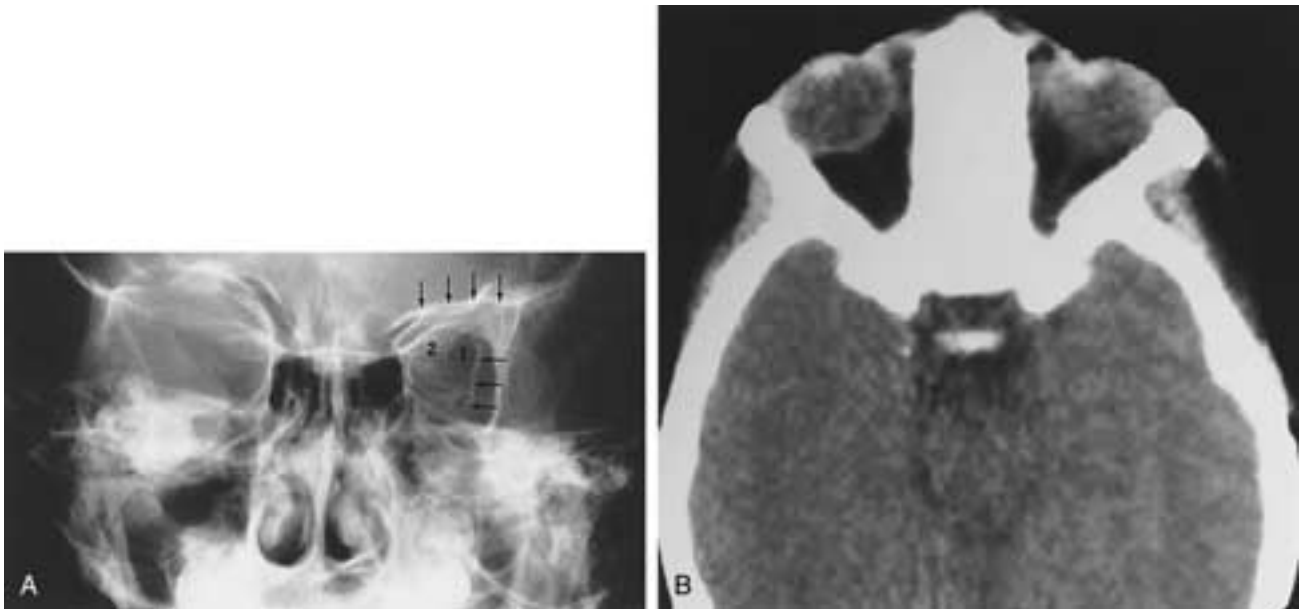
A, Microphthalmia. Posteroanterior view of the skull. The lesser wing of the sphenoid (2) and the left maxillary sinus are hypoplastic; superior orbital fissures are asymmetric (I). Note the difference between the oblique lines (*horizontal arrows*), which represent cortices of the temporal surface of the greater wings of the sphenoid bone. Notice the hypoplasia of the roof of the left orbit (*vertical arrows*). B, Microphthalmia. Four-year-old boy born without a nose and with left microphthalmos and apparent hypertelorism. The left globe is smaller than the right. Increased soft tissue between the medial wall of orbit and the globe anteriorly has the clinical appearance of hypertelorism. In fact, the interorbital bony distance is normal. (From Mafee MF et al. CT in the evaluation of the orbit and the bony interorbital distance. AJNR 1986;7:265.)
